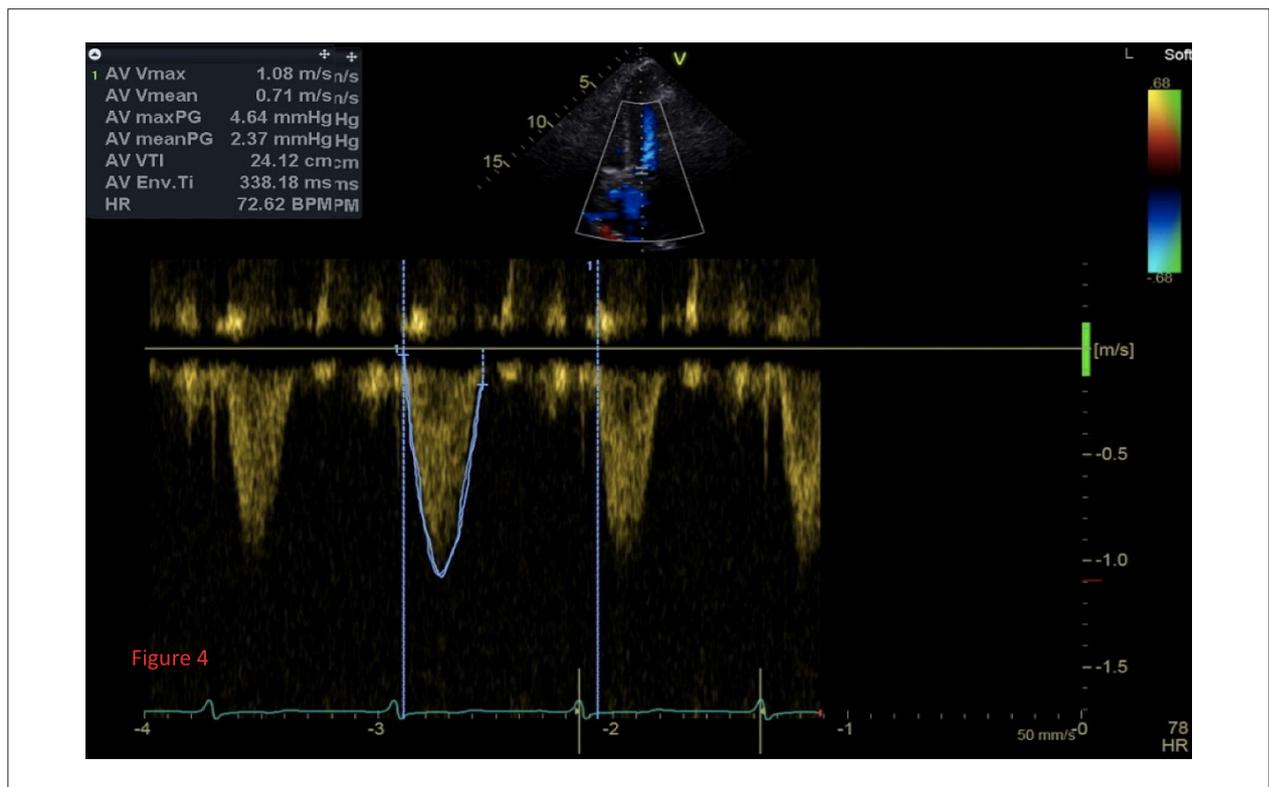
Postoperative echocardiography indicated that aortic valve velocity and pressure gradient improved significantly.
